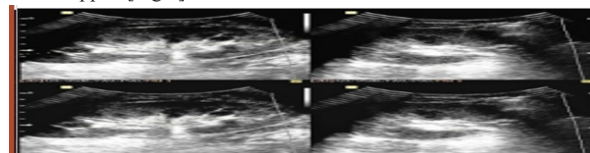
Graft length and graft parenchymal thickness measurement by grey scale sonography.
